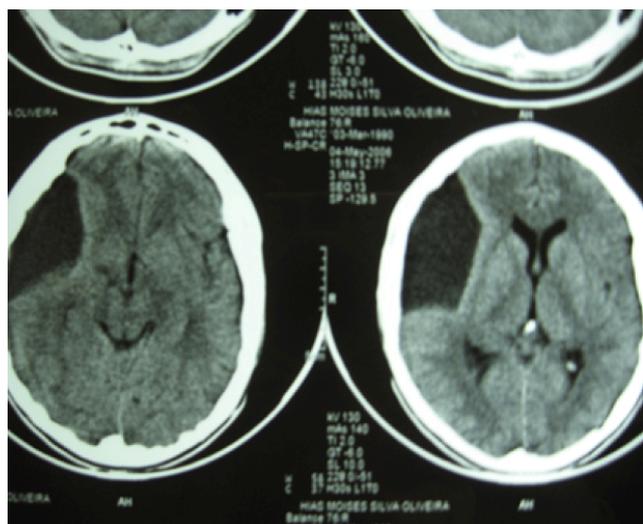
A second CT of brain showing a cortico-subcortical hypodensity measuring 3.78 x 1.39 cm, located in the right temporal lobe.
